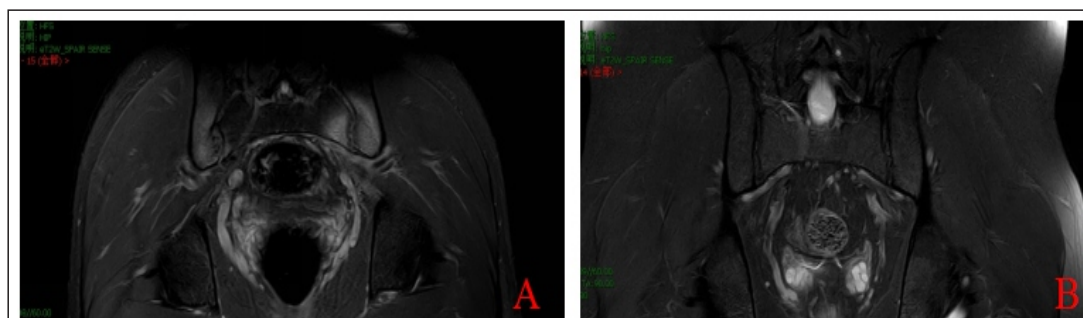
A: Before treatment, the coronal MRI T2WI of the sacroiliac joint showed a large area of BME. B: After treatment, the coronal MRI T2WI of the sacroiliac joint showed reduction in the BME basically, and only a small amount of the right sacroiliac joint hyperintense signal.
